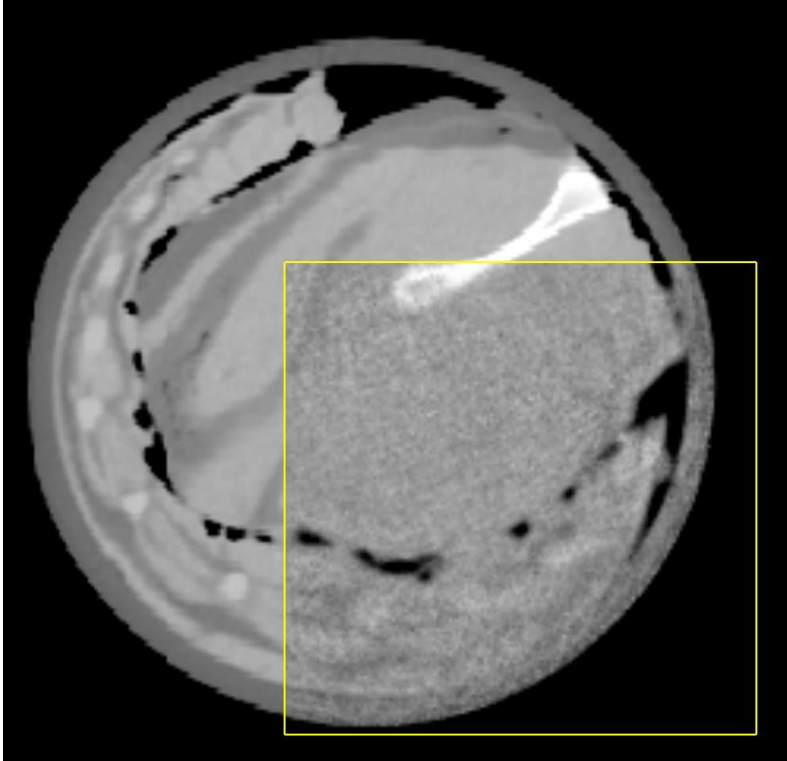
Pork tissue axial image on a CT slice with high contrast in soft tissue separating muscle and fat.
